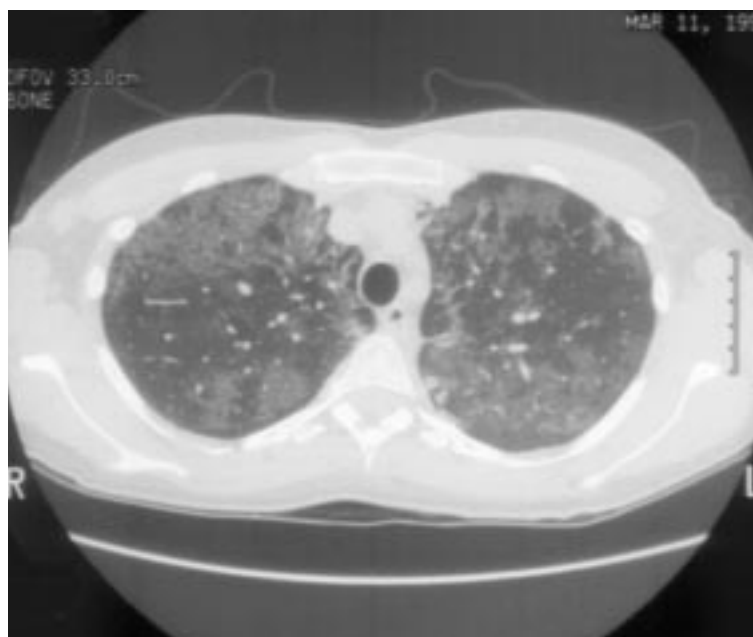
Chest computed tomography reveals bilateral, well-delineated alveolar infiltrates typical of PAP.
